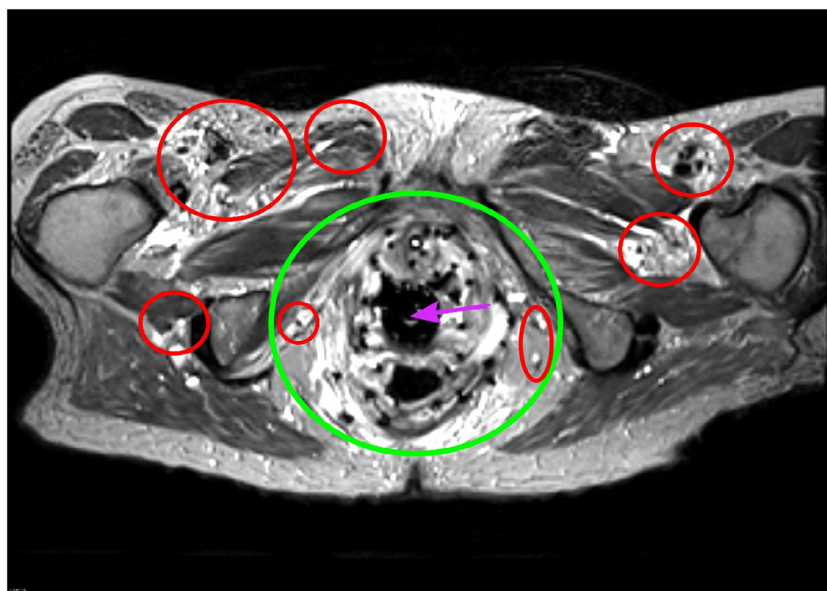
Example case of gynecologic brachytherapy intraoperative MRI. The green circle delimits the area where 35 catheters were placed. The red circles highlight areas containing anatomical structures (e.g. blood vessels) that appear very dark, similar to catheters and can be mistaken for catheters both by operator and by automatic algorithms. Purple arrow points to the center of the obturator shaft area.
